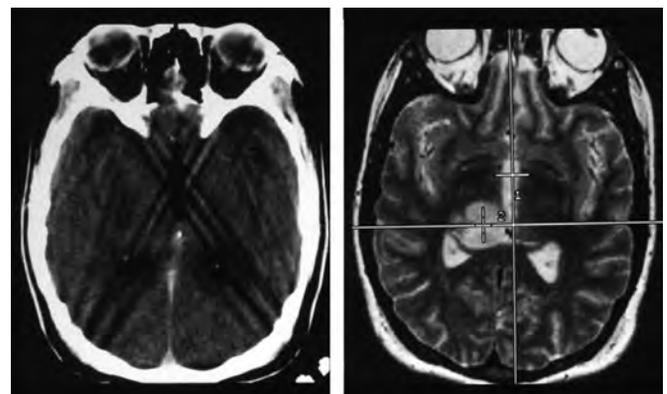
Frames provide precision and reliability. Certain lesions are best seen with MRI. CT imaging (left) showed poor contrast enhancement and pin artifacts compared with enhanced MRI (right) for this thalamic glioblastoma.
